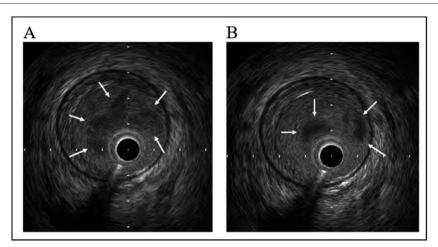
Intravascular ultrasound of the left main trunk shows a low echogenic lesion suggestive of a thrombus (arrow). (A) Proximal lesion and (B) distal lesion.
